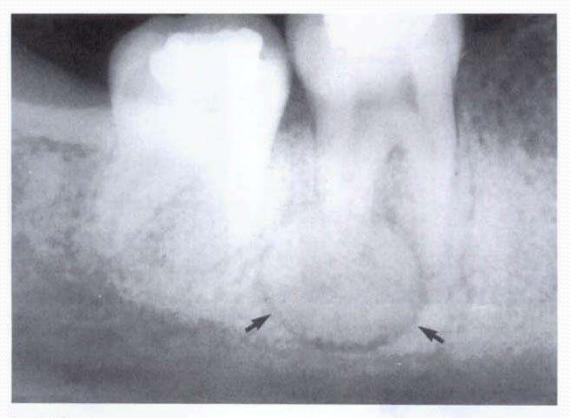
Periapical radiograph showing the typical appearances of a cementoblastoma, a radiopaque mass with a radiolucent rim attached to the root apex. (By kind permission of Mr E Whaites.)
